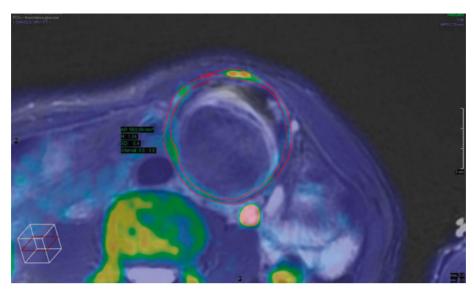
Region of interest (ROI) drawn around aneurysmal wall on volume matched T2 weighted MRI and PET image when calculating standard uptake values (SUV)
